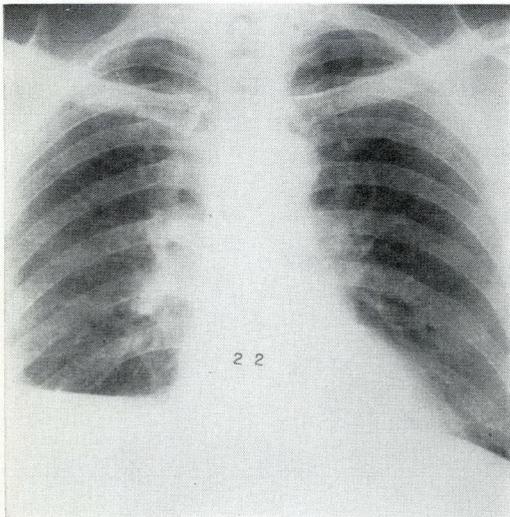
Case 6—thymic cyst. Postoperative chest radiograph.
